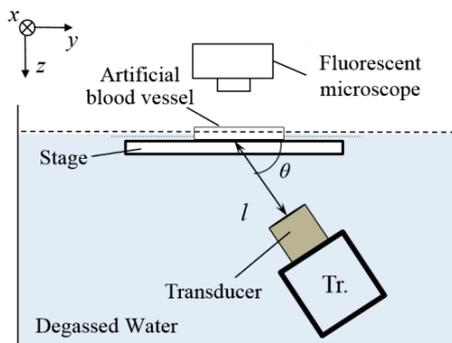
Experimental setup to expose ultrasound to suspension of BSCs in an artificial blood vessel.
